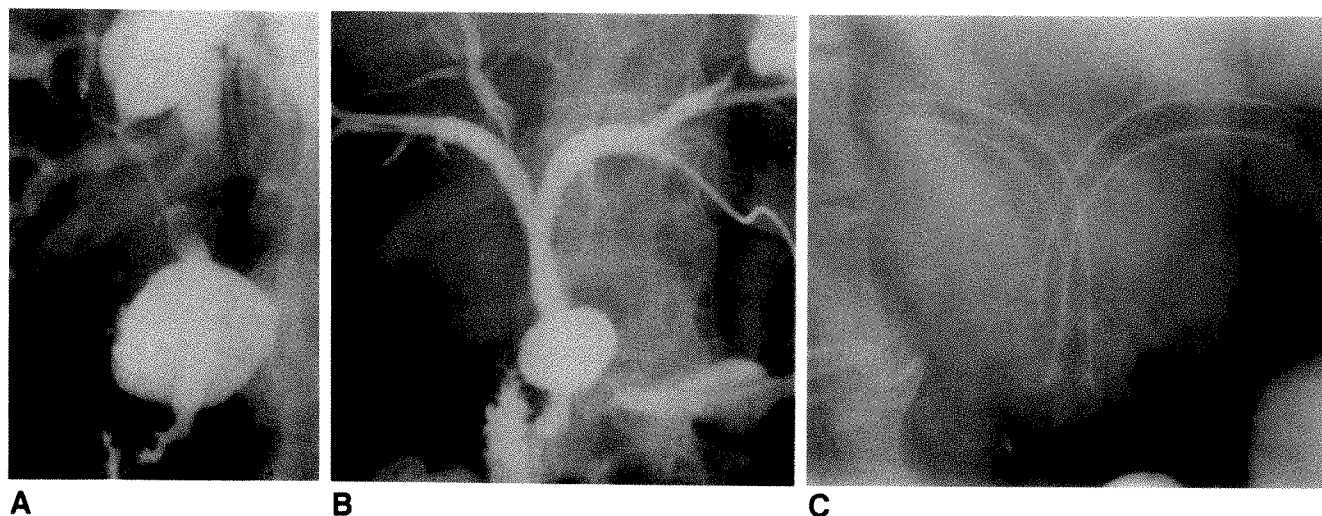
Radiographs of 58-year-old woman with cholangiocarcinoma.
